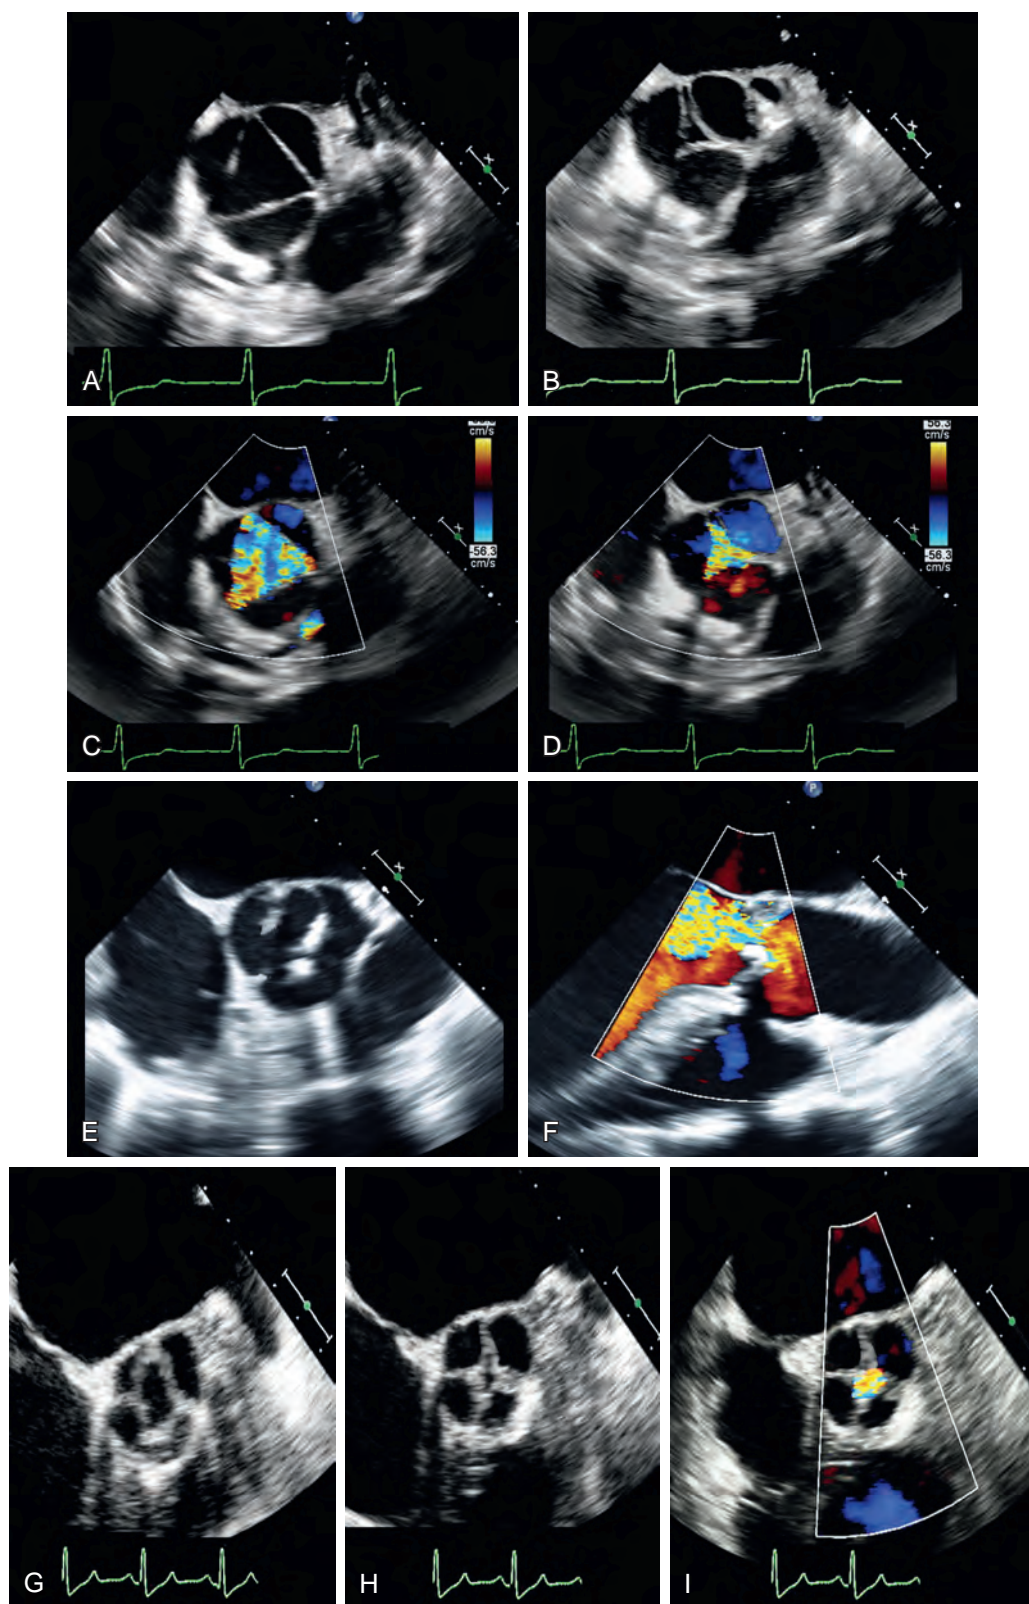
Aortic valve (AV): bicuspid, trileaflet, quadricuspid. (A) and (B) Trileaflet valve associated with a dilated aorta. (C) The same valve during ventricular systole. (D) Centrally directed aortic insufficiency (AI) jet. (E) and (F) Bicuspid valve with AI. Bicuspid valves may manifest with either primary stenosis, regurgitation, or a mixed dysfunction. Associated disorders may include aortic root dilation, aortic coarctation, and/or mitral valve degenerative disease. (G–I) Quadricuspid AV during systole (*left*), and diastole (*middle and right*). The color Doppler analysis shows mild to moderate AV insufficiency. AV insufficiency is the predominant finding/dysfunction for quadricuspid valves. Of note, unicuspid valves (not shown) manifest primarily with stenosis.
